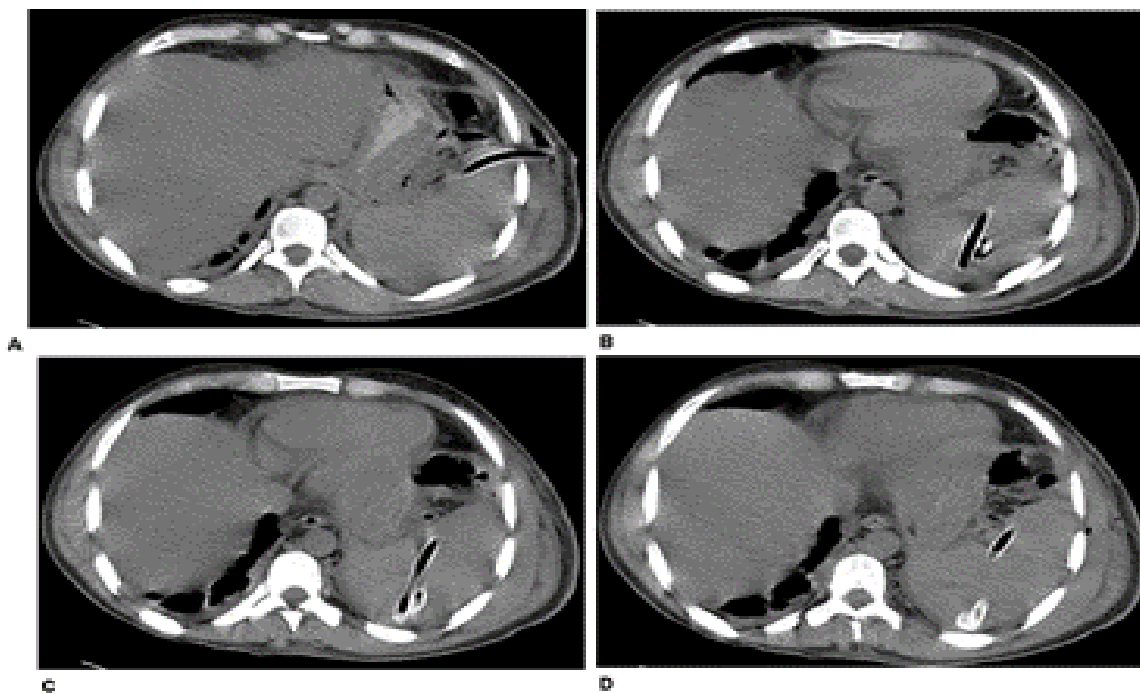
(case 8): A 27 years old male with acute pancreatitis and left pleural effusion. The chest tube was inserted on emergency bases and the tube failed to drain. CT then was done to evaluate the tube position
